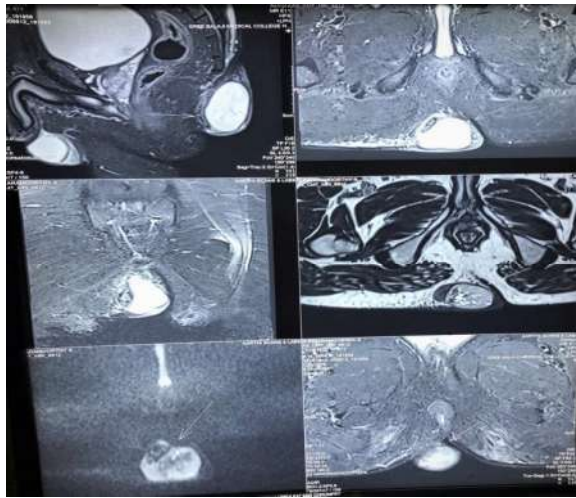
MRI T2 hyperintense solid mass in gluteal region
